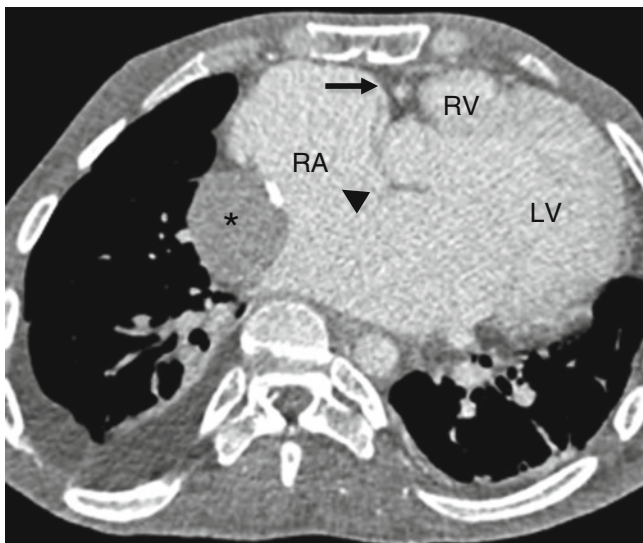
Tricuspid atresia with an atrial septal defect. This axial computed tomogram shows a fatty separation of the right atrium from the right ventricle (*arrow*), a hypoplastic right ventricle (*RV*), and enlarged right atrium (*RA*). A large atrial septal defect is noted (*black arrowhead*). *Asterisk*: extracardiac Fontan conduit. *LV* left ventricle
